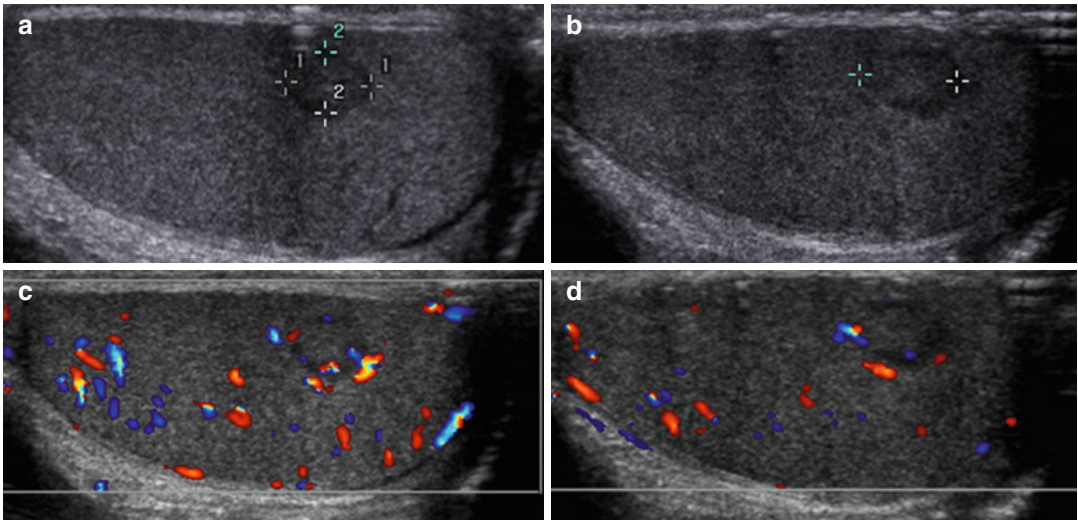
Ultrasound scans in child with incidental finding of testicular tumor. Note the hypochoic focal lesions (a,b), with irregular shape and margins, peripheral
